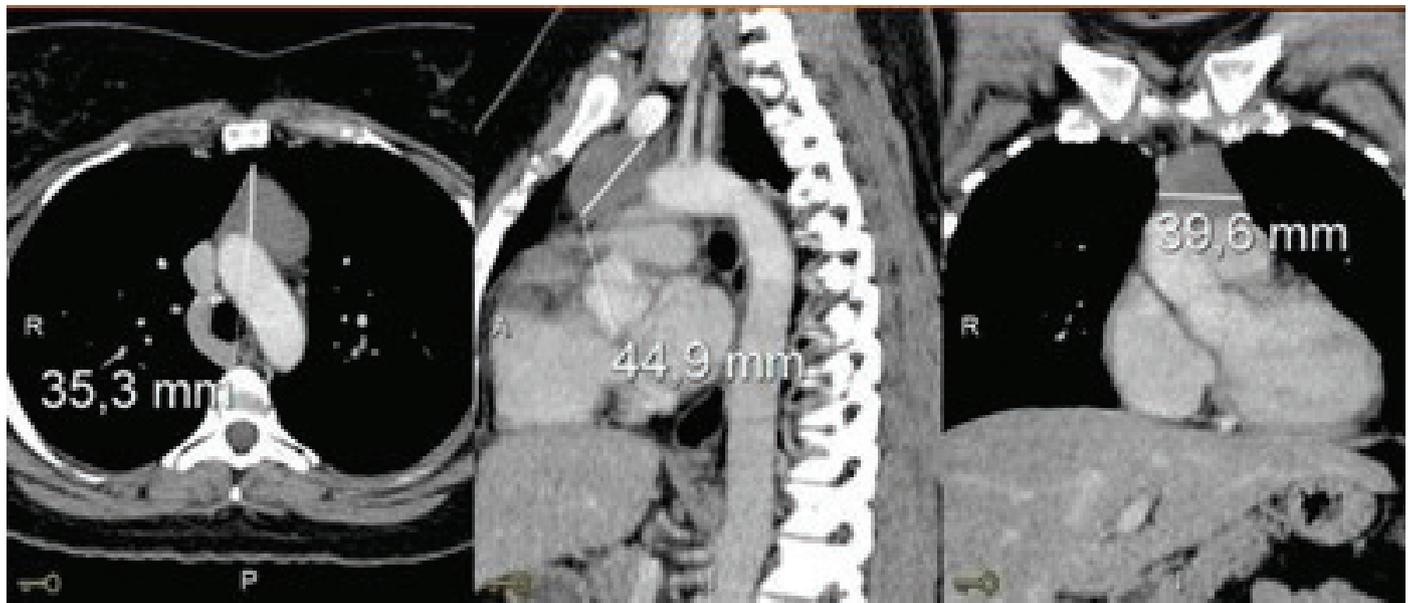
Tomography computed tomography of the thorax evaluating Mass in the anterior mediastinum of the patient .
